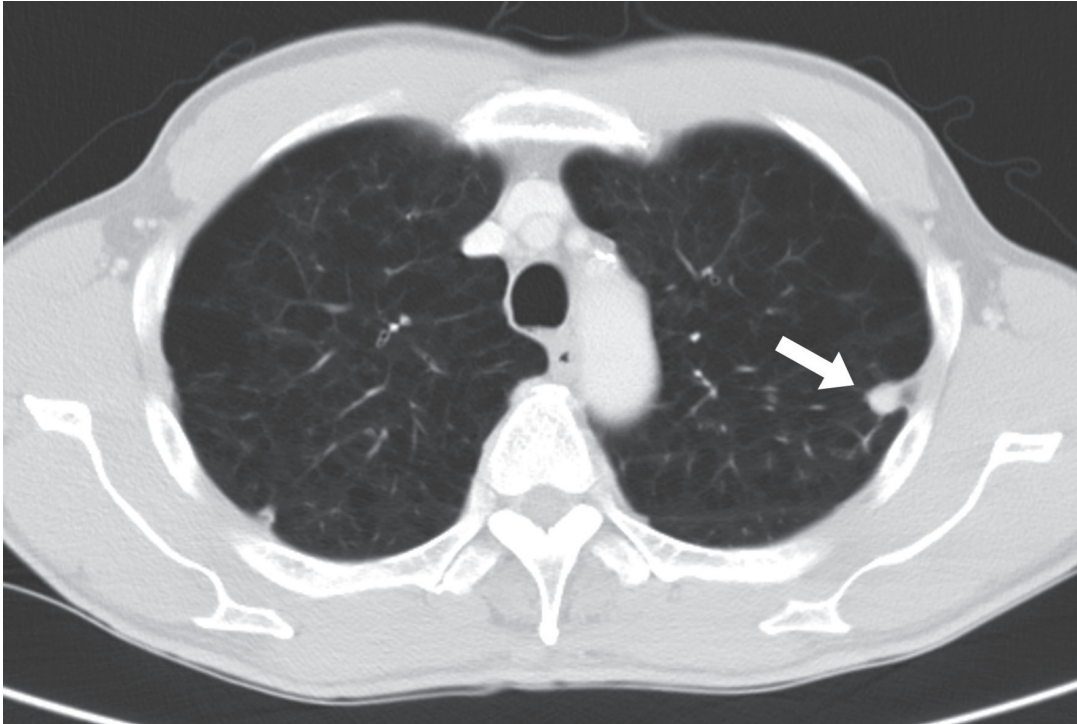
Chest computed tomography showed a subpleural solid nodule in the left upper lung.
